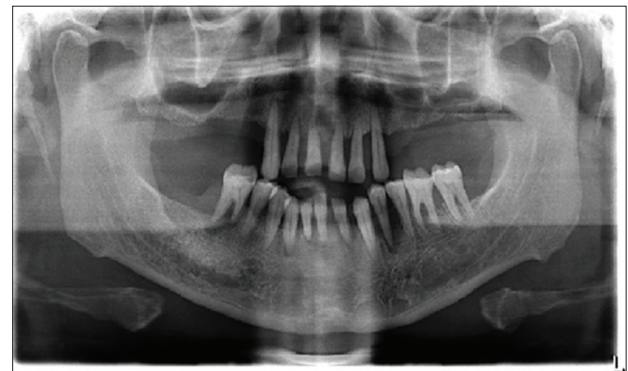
Orthopantomograph showing generalized bone loss till apical one-third of the teeth and with poorly defined (lost) lamina dura
